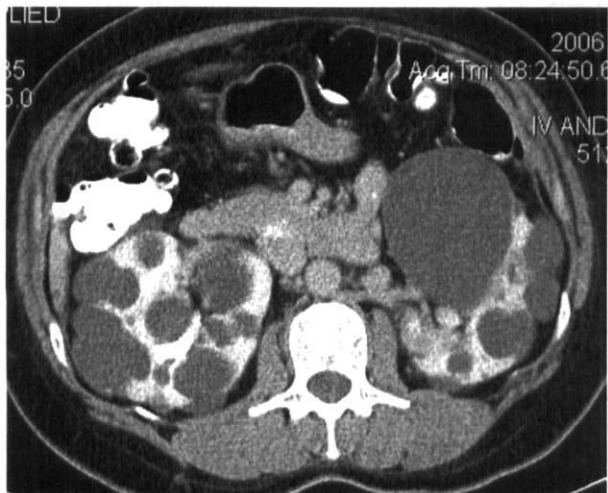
Abdominal CT scan showing massive kidneys with innumerable fluid-filled cysts.
